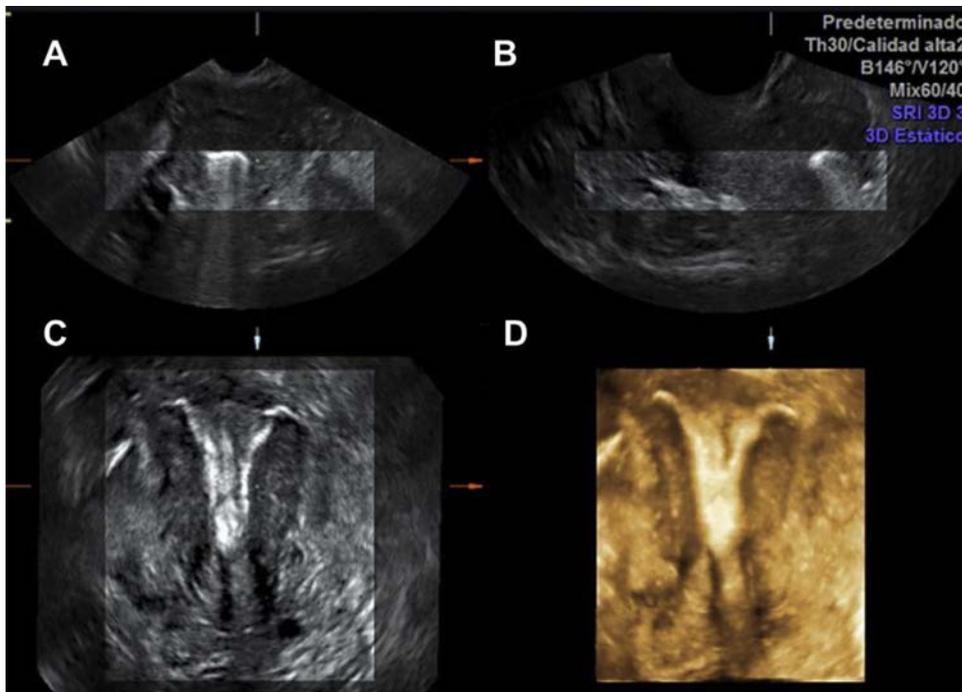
Multiplanar and three-dimensional transvaginal ultrasound images from hysterosalpingo-foam sonography (HyFoSy) in the (A) transverse, (B) sagittal and (C) coronal planes. (D) Reconstructed image in the coronal plane of a uterus demonstrating a normal uterine fundal contour and tubes filled with foam. Hyperechogenic foam (ExEm Foam) has filled the endometrial cavity and passed through the Fallopian tubes.
